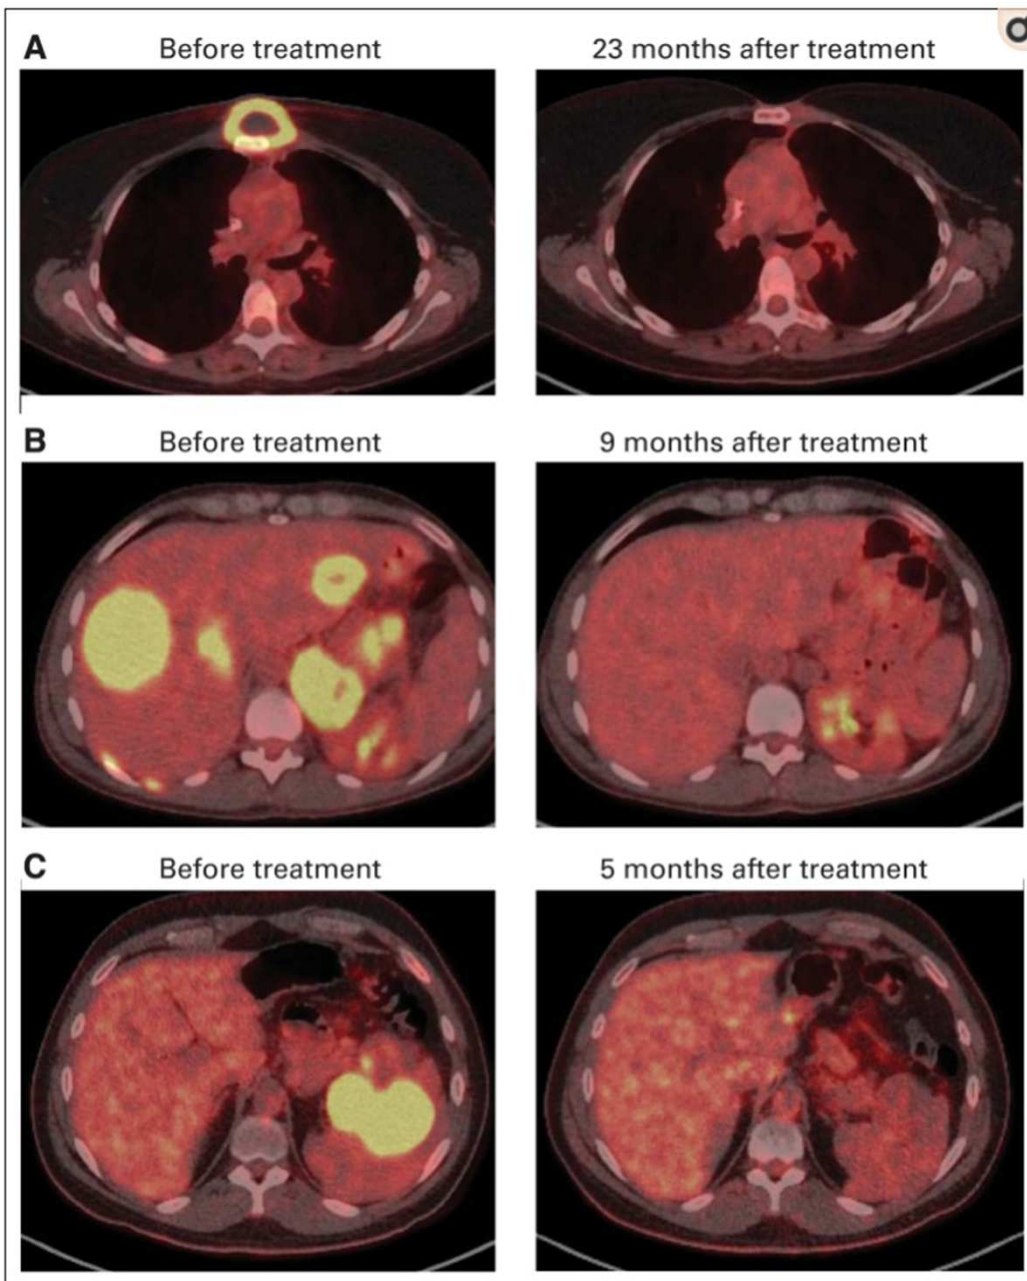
Complete remissions (CRs) of chemotherapy-refractory large-cell lymphomas in patients receiving anti-CD19 chimeric antigen receptor T cells. (A) Positron emission tomography (PET)/computed tomography (CT) scans show CR of chemotherapy-refractory primary mediastinal B-cell lymphoma (PMBCL) in patient No. 2. (B) PET/CT scans demonstrate CR of lymphoma in patient No. 8 who had chemotherapy-refractory PMBCL with extensive liver involvement. (C) PET/CT images show CR of diffuse large B-cell lymphoma, not otherwise specified, in patient No. 14, who had extensive splenic lymphoma.
